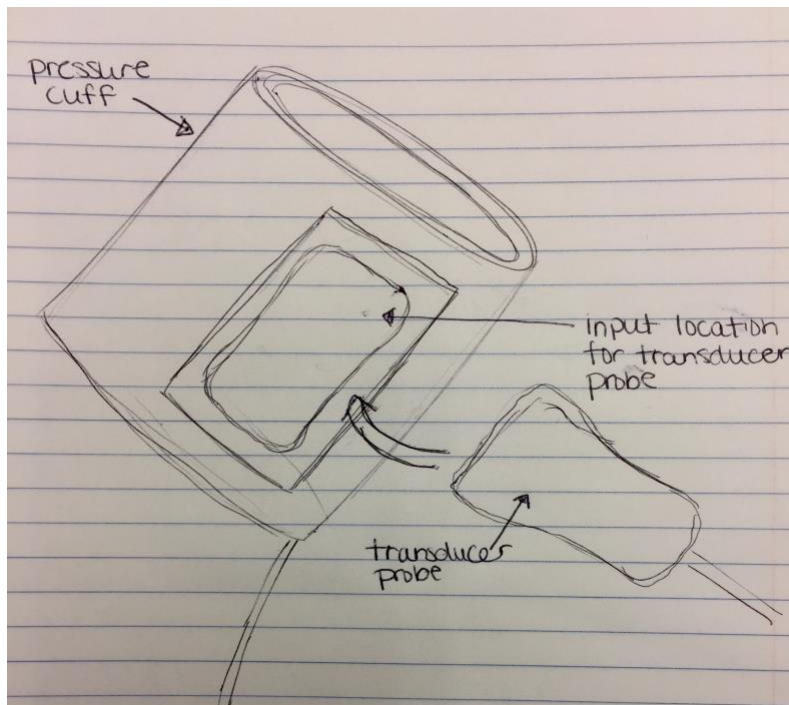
Concept 2—Description and Justification: This design consists of a blood-pressure type cuff, allowing for a flexible adapter for the ultrasound while keeping the device stable on the imaging area. However, this device is not compatible with the shoulder.
